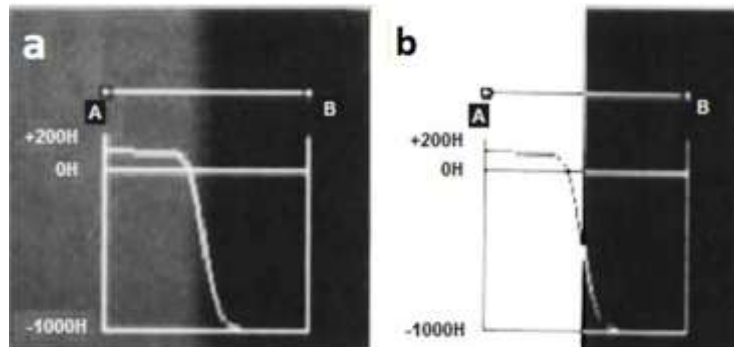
Computed tomography image showing the grey-level gradual change in a plexiglass-air interface. (a) Between points A (plexiglass) and B (air), grey levels go from 130 to -1000H, with a blurred boundary. (b) The actual interface is located where defined by the HMH. Adapted from Spoor et al. (1993).
